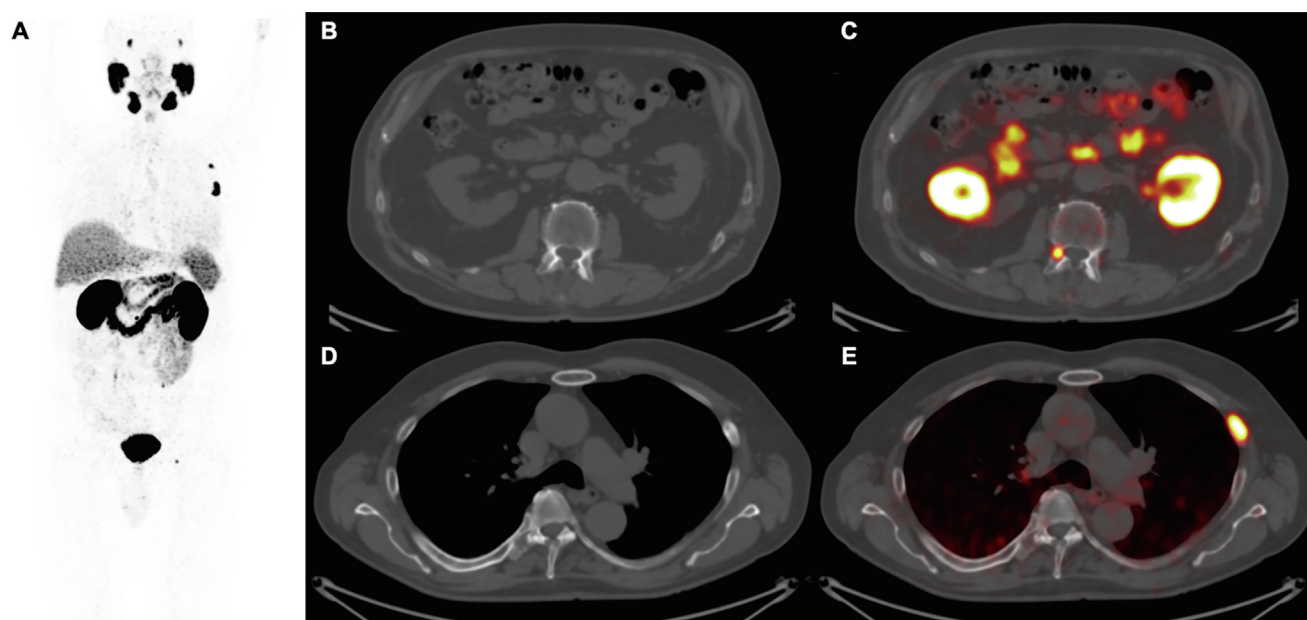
A 61-yr-old man underwent radical prostatectomy with pelvic lymph node dissection (iPSA = 7.5 ng/ml, pT3a pN0, ISUP 4, negative surgical margins). PSA at 6 wk after surgery was 0.06 ng/ml. Seven months later, first BCR occurred (PSA = 0.22 ng/ml, PSAdt = 3.4 mo). Salvage radiotherapy was scheduled as the best clinical practice option. The patient was referred to PSMA-PET. The predicted probability of positivity applying our nomogram was 72%. Indeed, PSMA-PET revealed (A) four bone metastases with high PSMA uptake, (B and C) two lesions without significant CT alterations, and (D and E) two other lesions corresponding to two osteosclerotic lesions on CT. The patient was treated with ADT instead of salvage radiotherapy. ADT = androgen deprivation therapy; BCR = biochemical recurrence; CT = computed tomography; iPSA = initial PSA; ISUP = International Society of Urological Pathology; PET = positron emission tomography; PSA = prostate-specific antigen; PSAdt = PSA doubling time; PSMA = prostate-specific membrane antigen.
